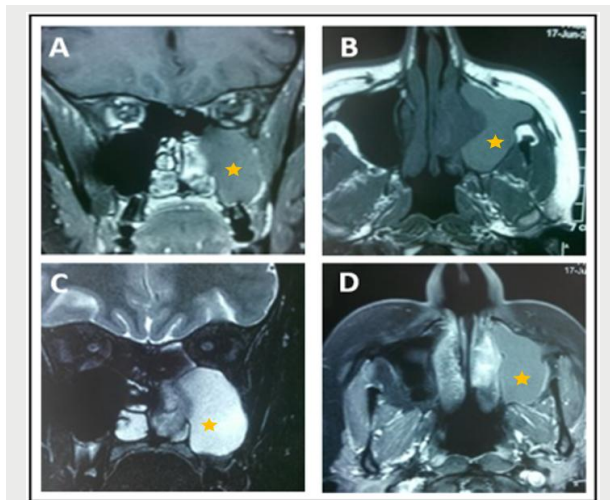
MRI of the facial area showing the tumor (yellow star) in the left nasal cavity with low T1 (Show in coronal (A) and axial (B) T1-weighted sequences), and high T2 signal (Shown in (C) coronal T2-weighted sequence). A moderate contrast enhancement is show in (D) an axial T1-weighted sequence after fat saturation and gadolinium injection.
